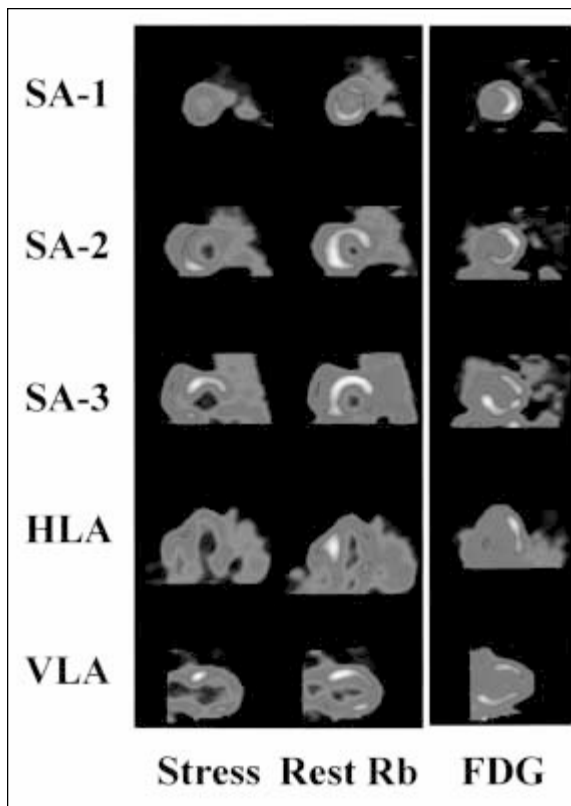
Stress and rest rubidium-82 PET myocardial perfusion images and FDG PET images in the same patient. The perfusion images show extensive partially reversible perfusion defects in the septal, inferior, lateral, and antero-apical regions. The FDG images show areas of perfusion-metabolism mismatch in the lateral and infero-basal regions (arrows) indicating hibernating but viable myocardium
